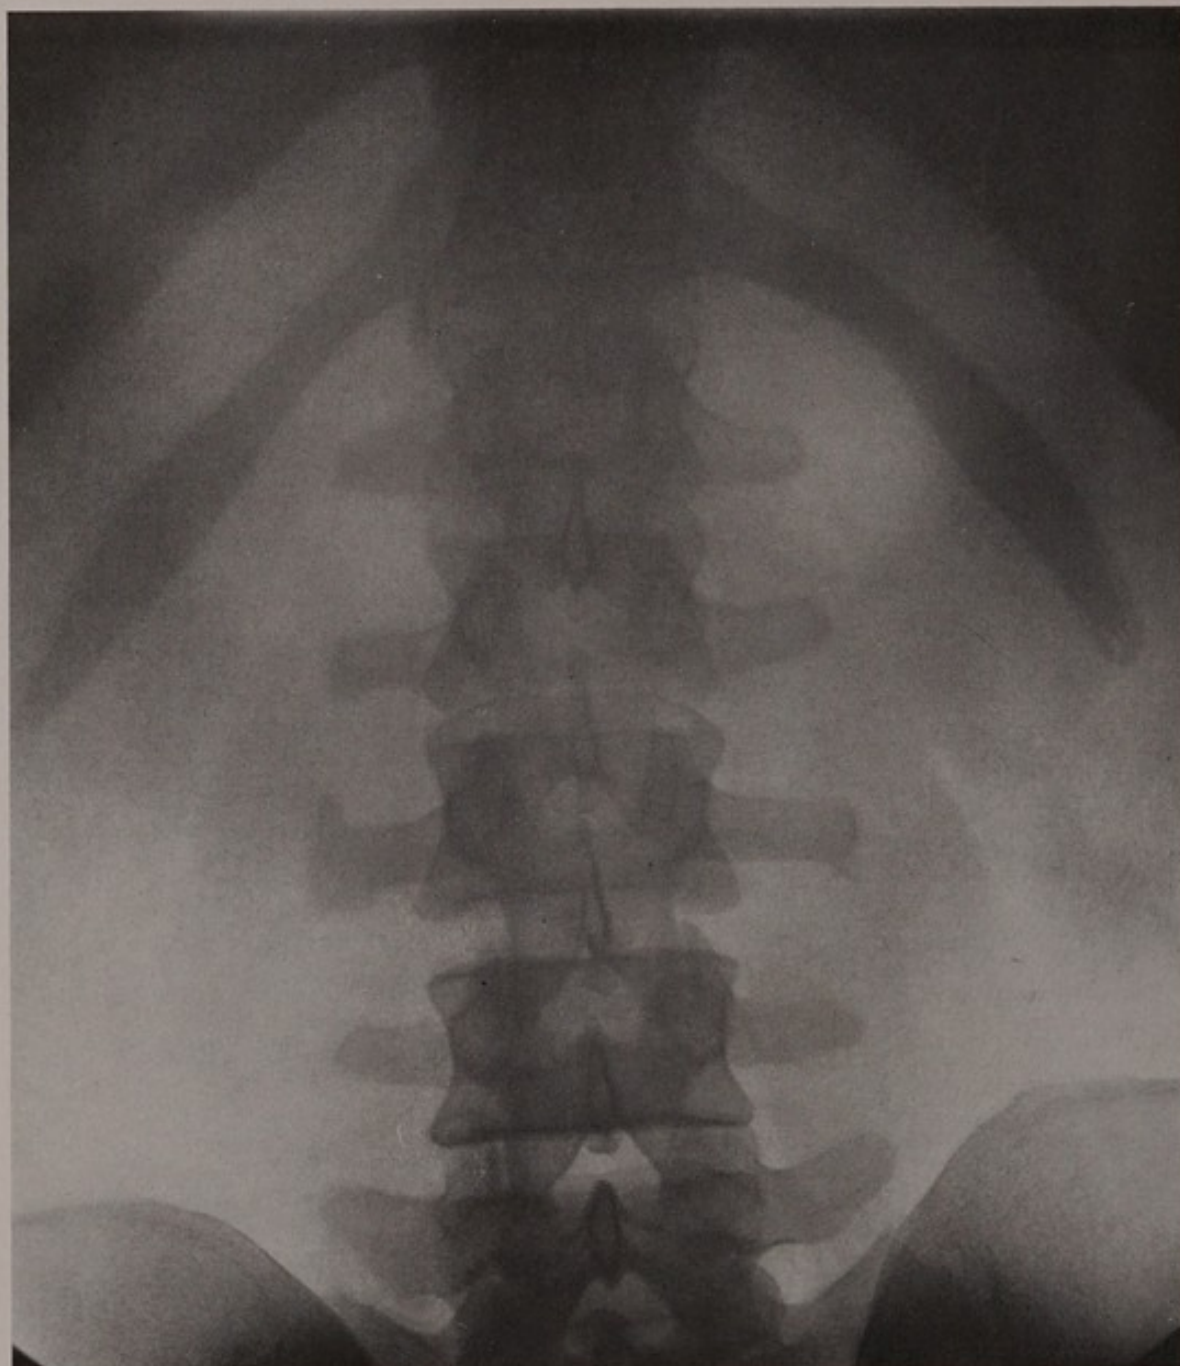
X-ray of the lumbar spine to show the size of the opening between the fourth and fifth vertebrae through which lumbar puncture is ordinarily performed.
